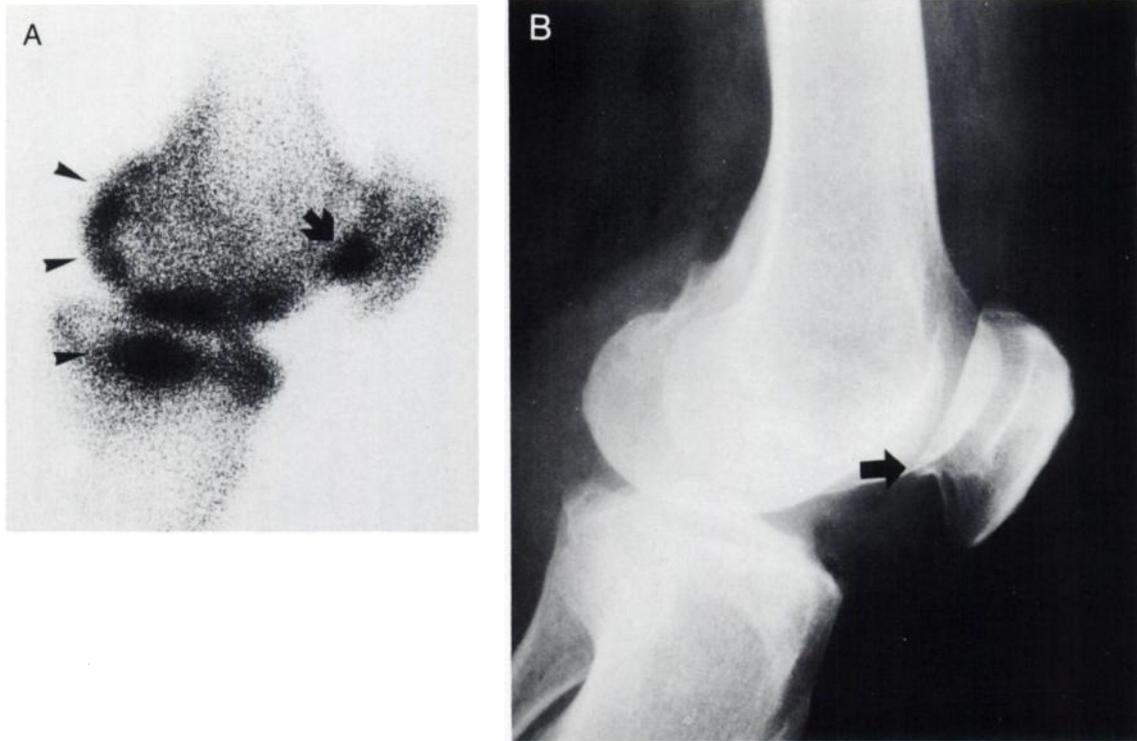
(A) Medial pinhole scintigraph of the osteoarthritic left knee and patella of Patient 7 shows small, discrete, spotty tracer uptake in the lower edge of the retropatellar facet (arrow) as well as multiple areas of spotty and segmental uptake in the femorotibial compartment, which is the site of the main pathology (arrowheads). (B) Lateral radiograph reveals an osteophyte arising from the lower edge of the retropatellar facet (arrow) and cortical irregularity and thinning of other peritarticular bones, indicating degeneration.
